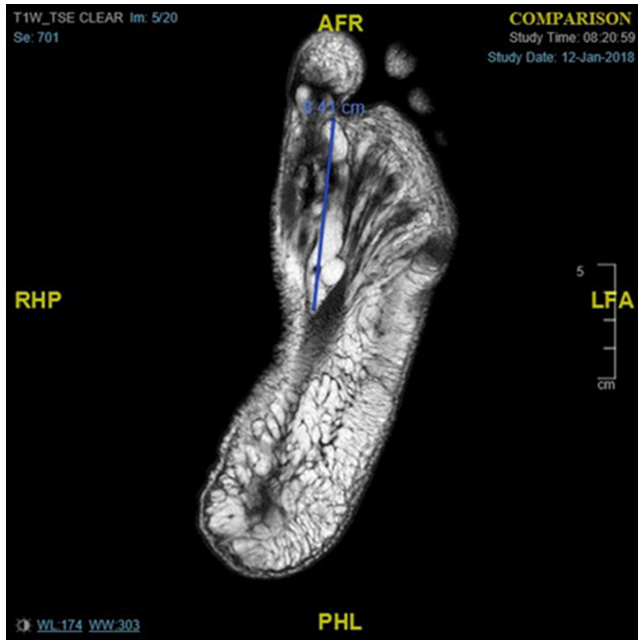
Pre-operative MRI images
